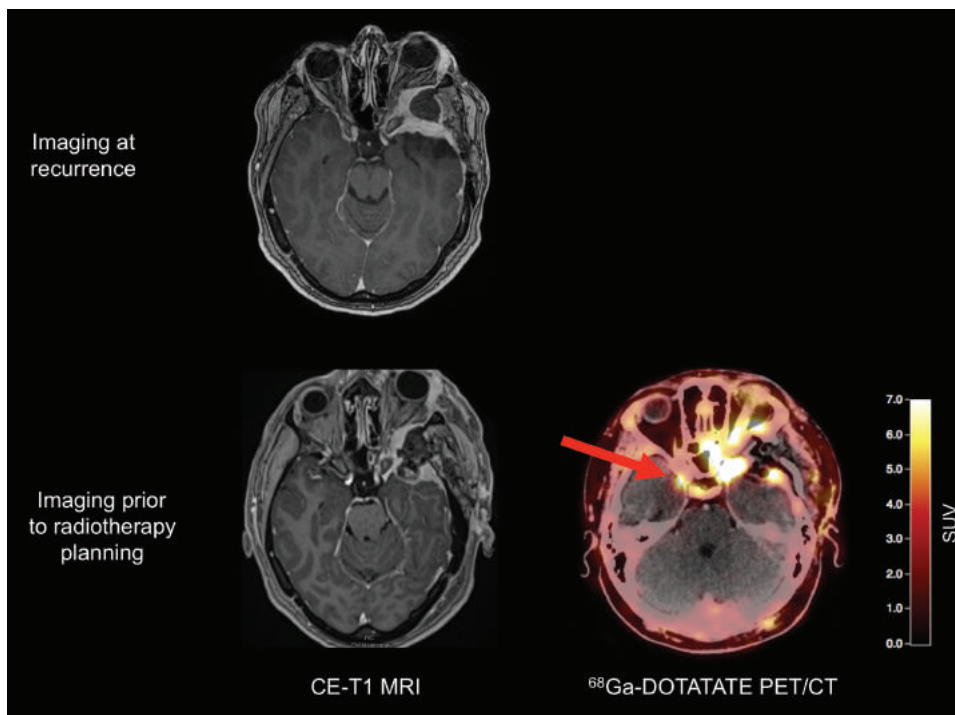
A 42-year-old patient with exophthalmos and a history of a left sphenoid wing meningioma. Preoperative MRI shows tumor recurrence (top). Postoperative MRI (bottom left) shows an incomplete resection of the tumor, necessitating adjuvant radiotherapy. For radiotherapy planning, ^{68}Ga -DOTATATE PET/CT reveals an additional tumor located at the tip of the right sphenoid wing (arrow, bottom right).
